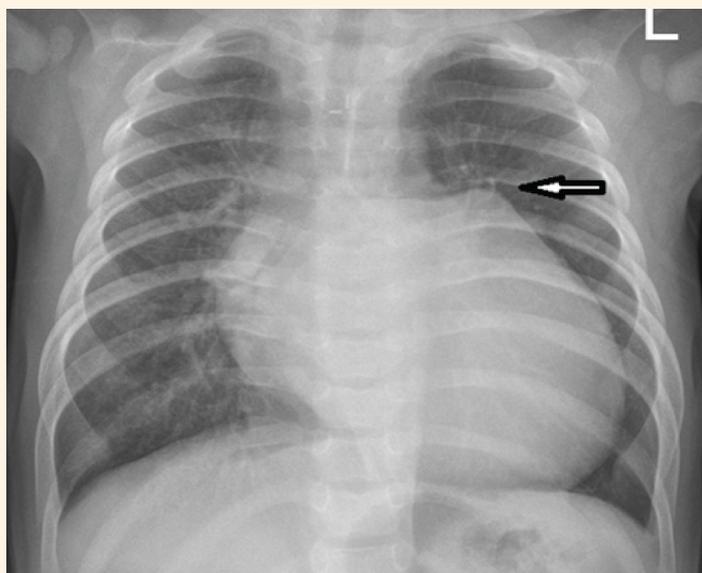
Plain X-ray Chest showing the third mogul on the left heart border (arrow).
